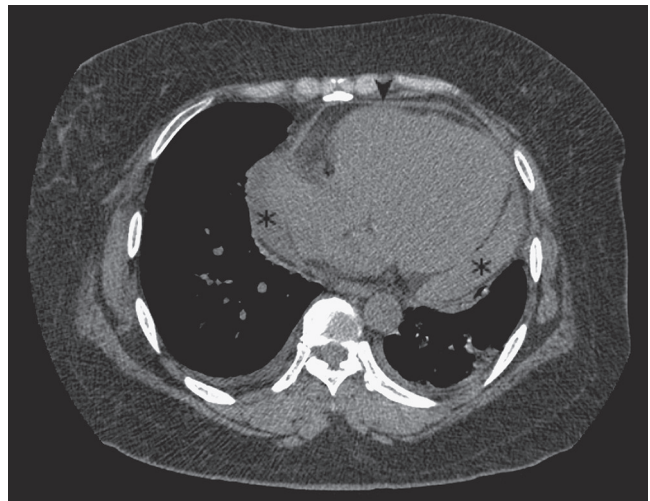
■ Pericardial effusion. Nongated cardiovascular computed tomographic image with a moderate pericardial effusion predominantly displayed in the dependent portion of the pericardium (*asterisk*) but also visible as a thin line at the anterior aspect of the heart (*arrowhead*).
